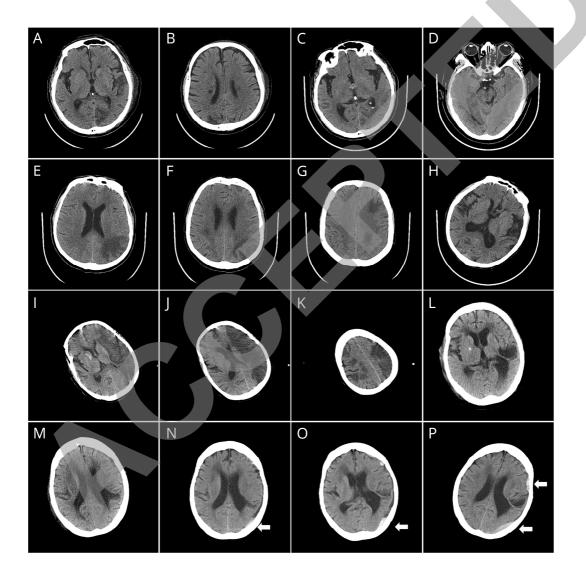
CT brain scans of COVID-19 cases with cerebrovascular accidents.
